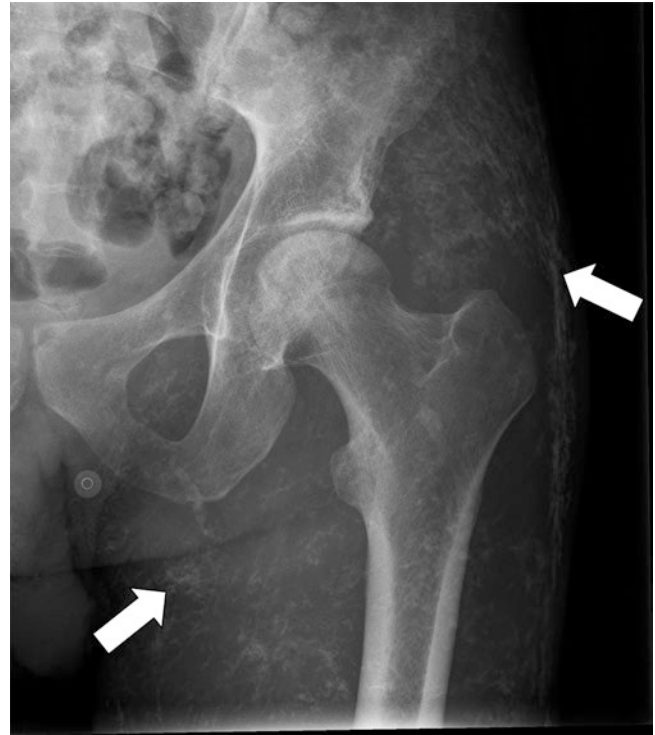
Anteroposterior radiograph of the left hip demonstrates “sheet-like” linear calcifications (white arrows) within the soft tissues in a patient with known dermatomyositis
